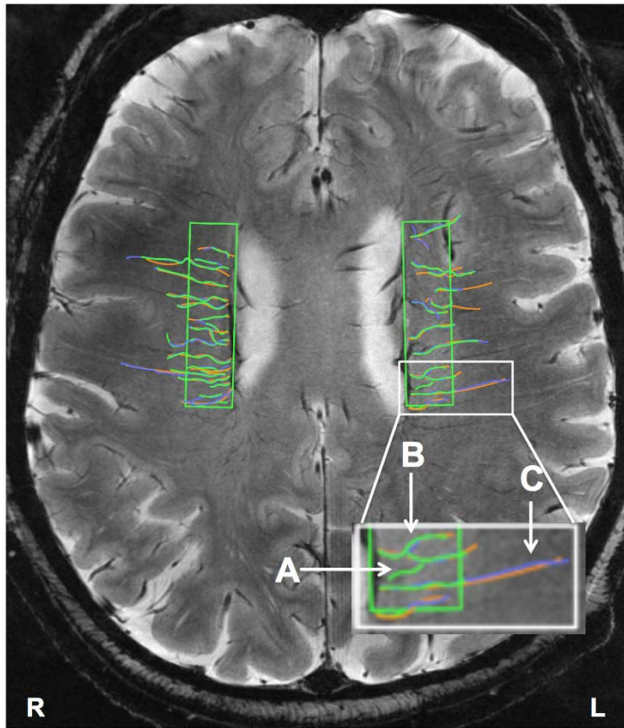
A sample consensus venular tracing on SWI MRI at 7 Tesla across ROIs in both hemispheres in the LIFE MRI study
